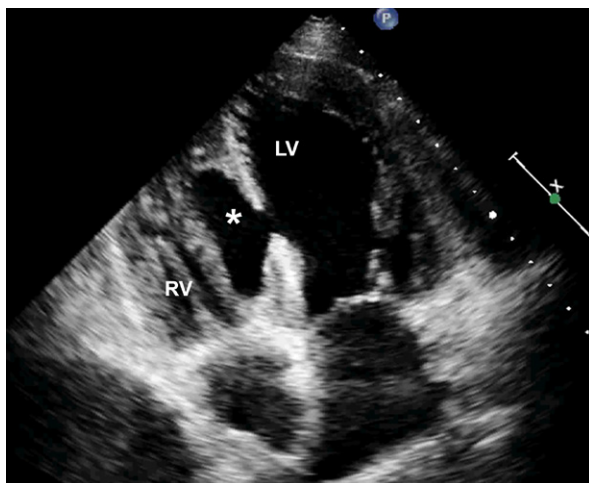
Transthoracic echocardiogram (B-mode, 4-chamber view) shows the intraseptal cavity (asterisk) and the opening into the left ventricle (LV).
